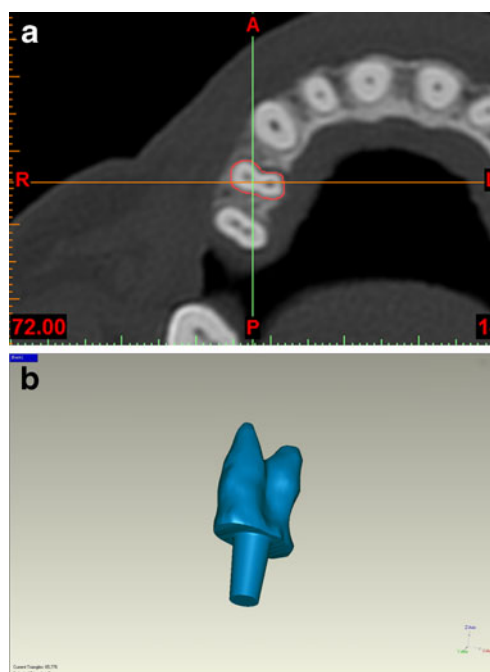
a Computed tomographic (CT) images of the fractured tooth: the residual root is isolated. b Stereolithographic (STL) file of the root-analogue implant (RAI) with the prosthetic conical abutment
